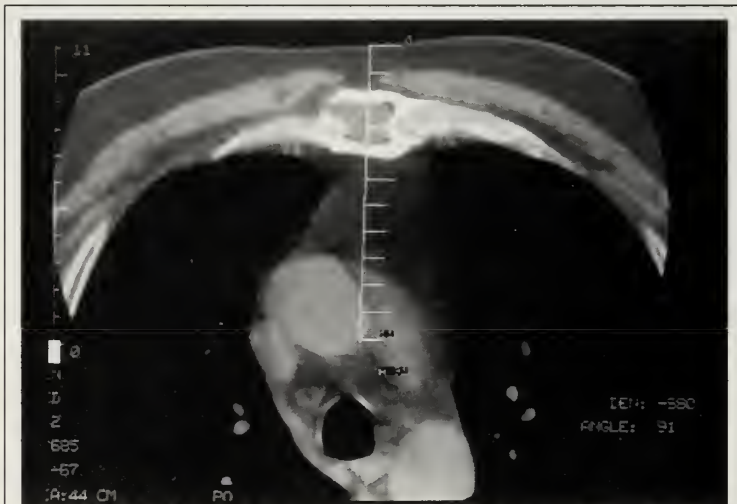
CT of sternum lower level demonstrating soft tissue mass within the marrow. Biopsy was performed which showed marrow necrosis and the presence of over 90% myeloma cells.
